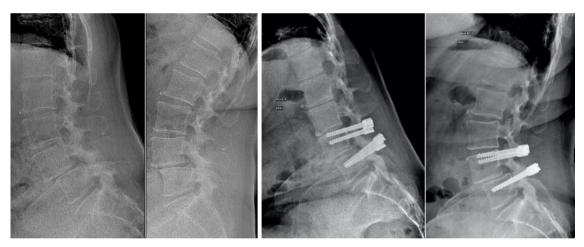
Dynamic X-Rays of L4L5 degenerative spondylolisthesis treated by Dynesys stabilization.
